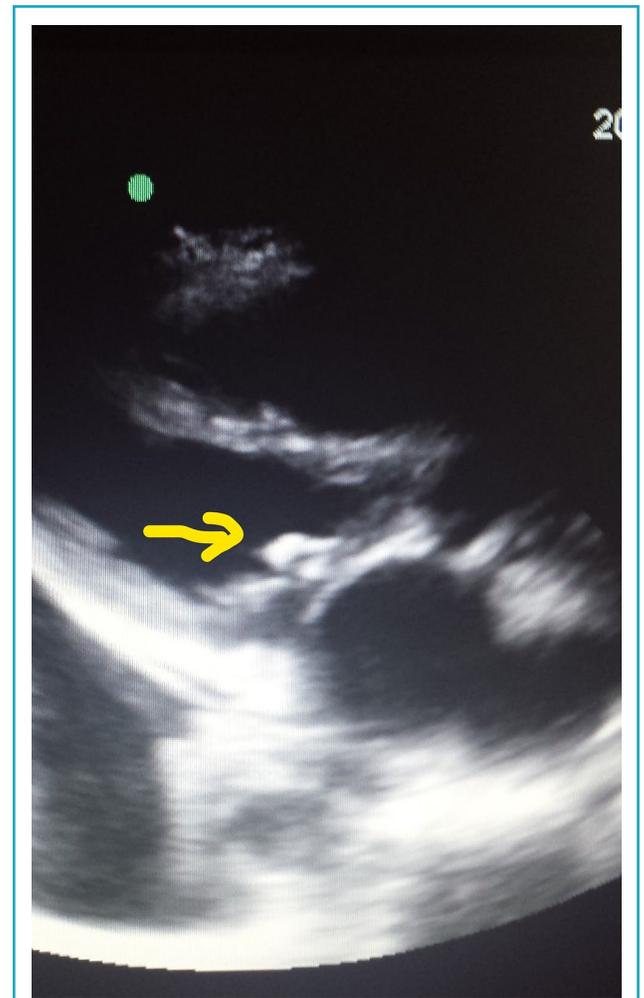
PLAX (Parasternal long axis) view of stenotic mitral valve; arrow indicates the stenotic lesion
